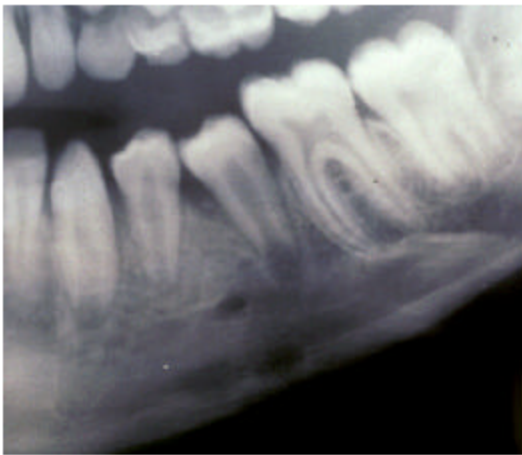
Panoramic radiograph showed multiple lytic lesions in the left posterior parts of the mandible
